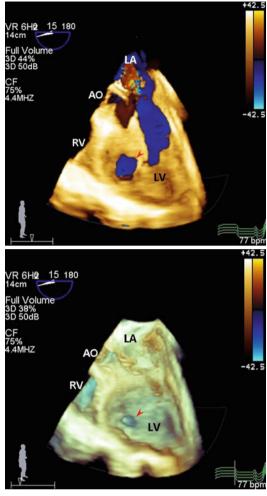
3D TEE color Doppler, four-chamber view, showed a post myocardial infarction apical VSD with a left to right shunt (*arrow*)
